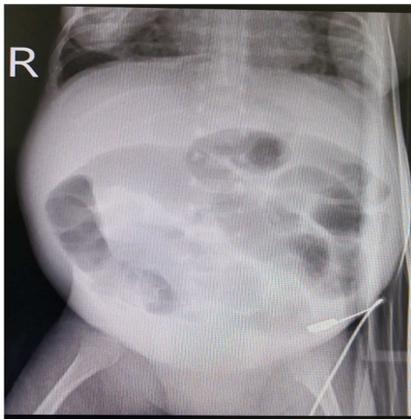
Children with preoperative abdominal plain radiographs indicate signs of intestinal obstruction.
